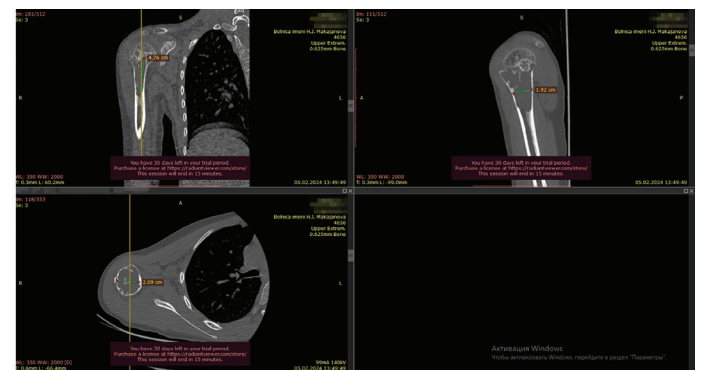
Dimensions of the inner walls of the cyst on CT scans
